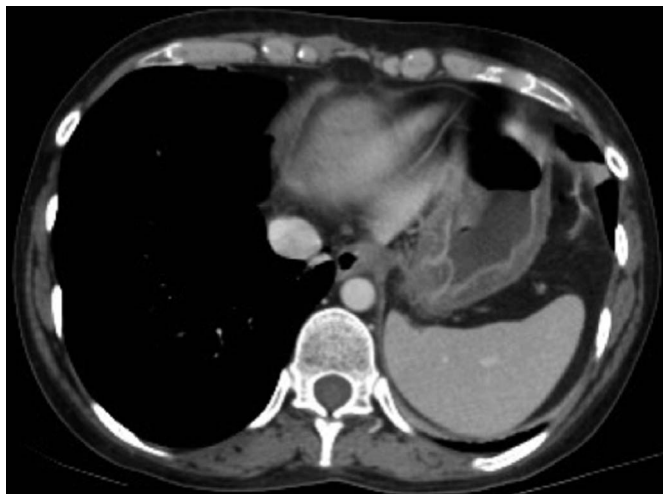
Abdominal computed tomography showing thickening of the gastric wall with mucosal enhancement.
